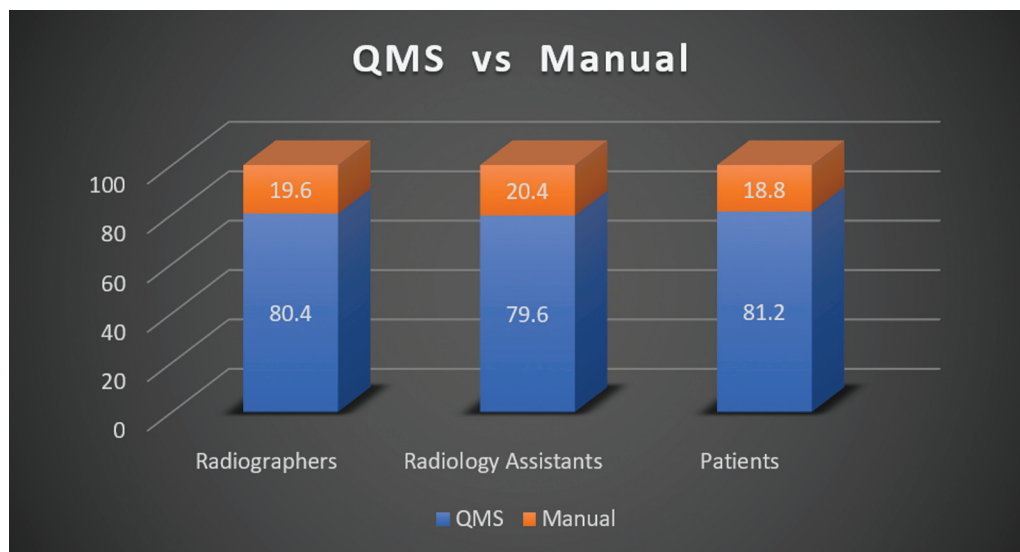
Comparison between queue management system (QMS) use and manual in chest radiography-tuberculosis (CXR-TB) screening among radiographers, radiology assistants, and patients, expressed in percentage. A strong level of agreement for QMS preference is recorded.
